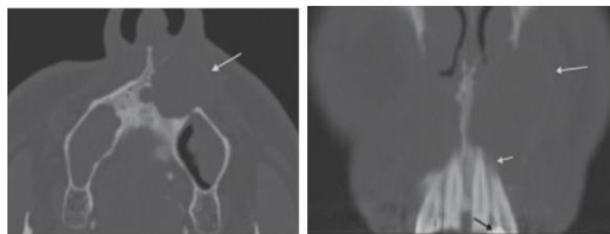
Radicular cyst. (A) Axial (CT) view with bone window shows an expansile cystic mass in the left maxillary alveolus. Note the thin, corticated rim (arrow). (B) Coronal bone CT shows that the cystic mass (long white arrow) is intimately associated with resorption of the root apex (short white arrow). Endodontal infection from the restoration (black arrow) was the culprit in this case.
